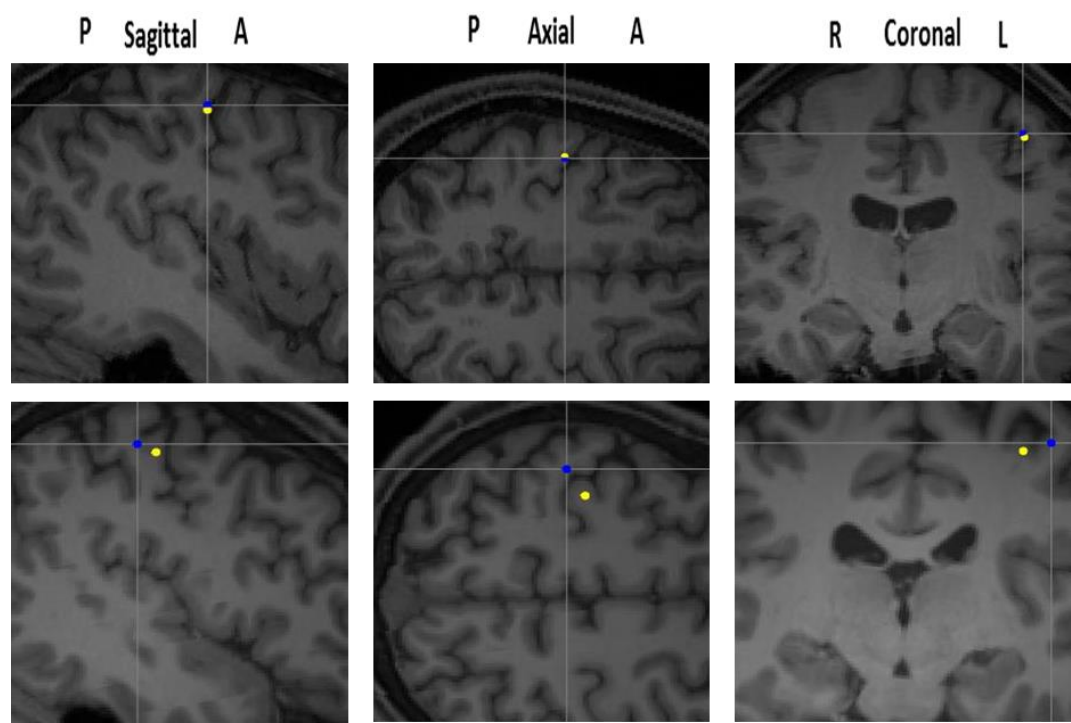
5 | Impact of different head models on dipole location for somatosensory evoked fields. The dipole locations for the different head models (yellow: single sphere and blue: single shell) obtained after SBM registration are plotted on T1w-MRI slices. The dipole location based on the single shell was used for MRI slice selection and the other dipole was projected onto these slices. Dipole B for Subjects IIb (upper row) and VII (bottom row).
